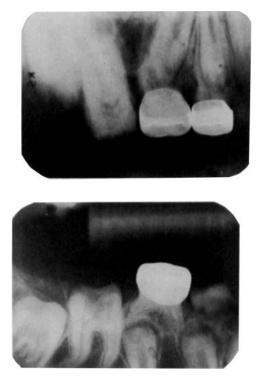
Radiographs of S.M. at 10 years show no enamel on the primary first molar or unerupted permanent teeth. Calcifications are present in the pulp chambers of the first permanent molars and an area of resorption appears to involve the lower molar crown.
